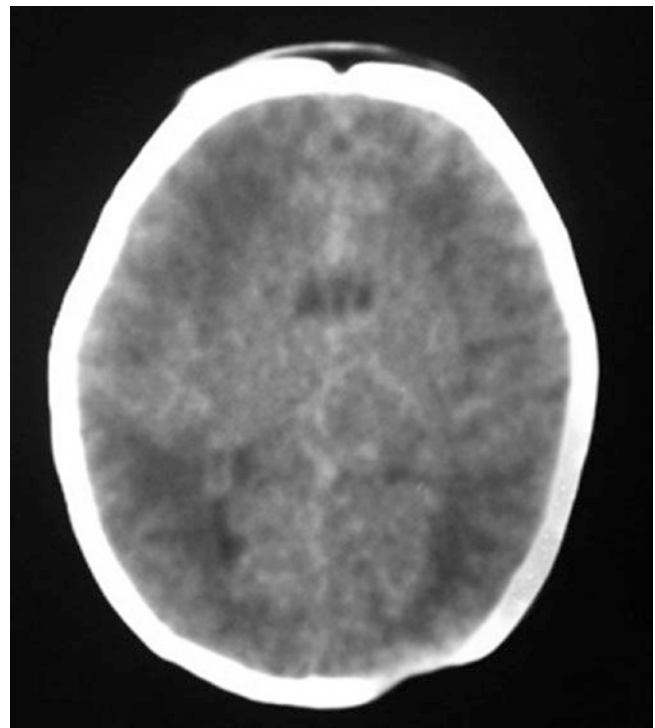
Axial CT image demonstrates focal bony deficiency in the posterior left skull, subjacent to an area of cutis aplasia
